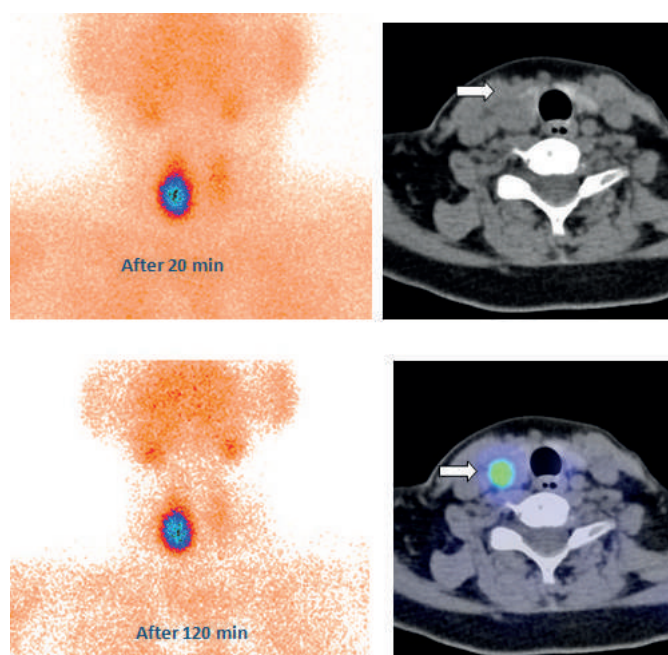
1A. Initial and delayed phases of planar Tc99m-technetrite scintigraphy showed increased activity in the right lobe (arrow). Technetrite could not be used to differentiate between a parathyroid lesion and a thyroid lesion. 1B. Axial non-contrast enhanced CT of the neck. 1A lesion
